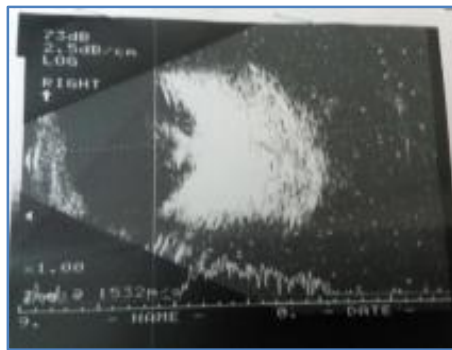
Ultrasonography of the Globe Shows a Retinal Detachment
